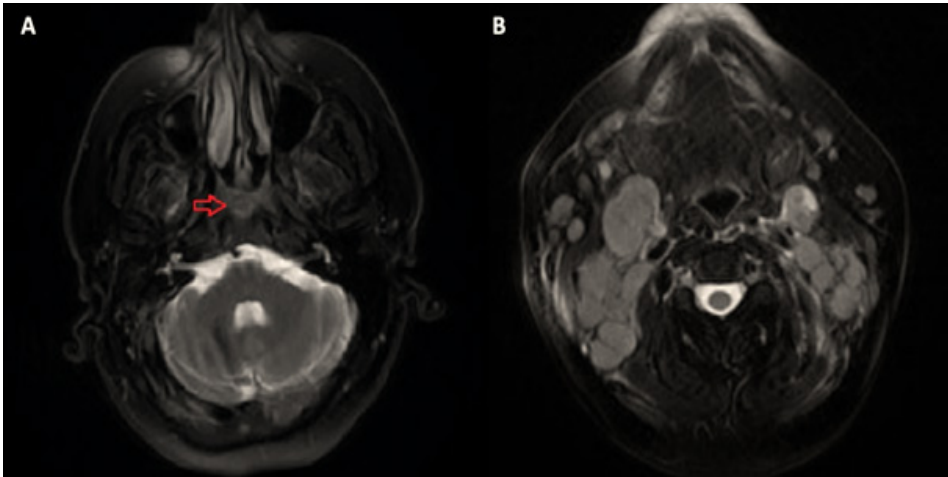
(A) Axial section of the nasopharyngeal MRI shows an asymmetrically thickness in the posterior wall of the nasopharynx at the right side. (B) Axial section of the cervical MRI shows multiple conglomerated lymphadenopathies in the bilateral cervical lymphatic chain.
